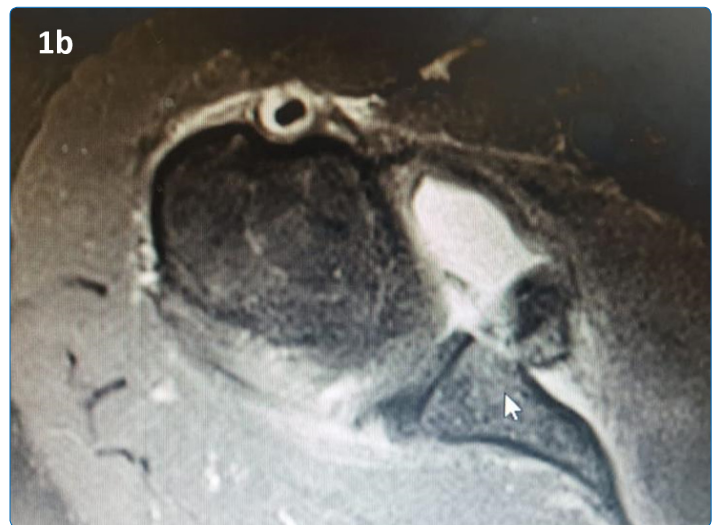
Axial MRI imaging
